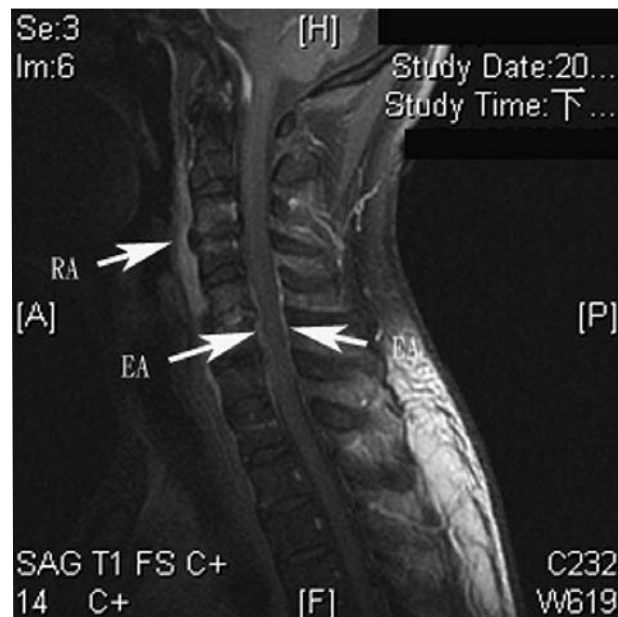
Magnetic resonance imaging of cervical spine. A T₂-weighted sagittal image before the operation revealed infectious spondylitis of cervical spine (C₂–C₇) with retropharyngeal (RA) and epidural (EA) abscesses at the anterior and posterior part of the spine, respectively.
